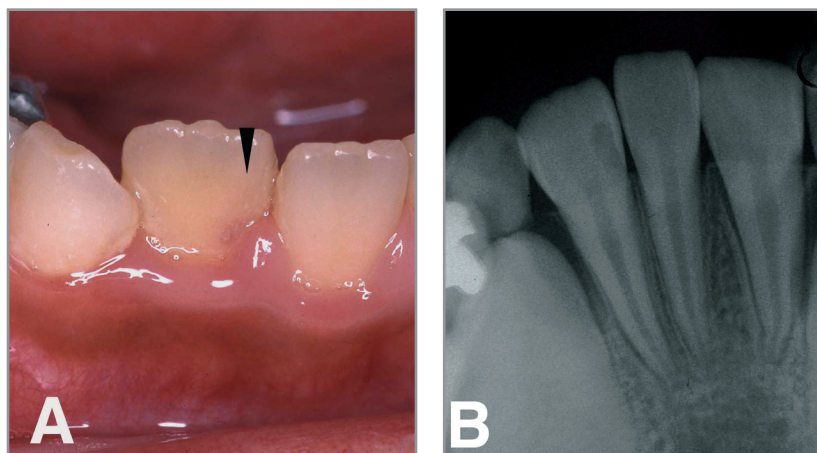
(a) Photograph of labial aspect of the permanent mandibular right lateral incisor showing a pink spot area (arrow). (b) Periapical radiograph at age 10 years 11 months showing a radiolucent defect in the dentin pulpal to the dentoenamel junction on the mesial surface.
